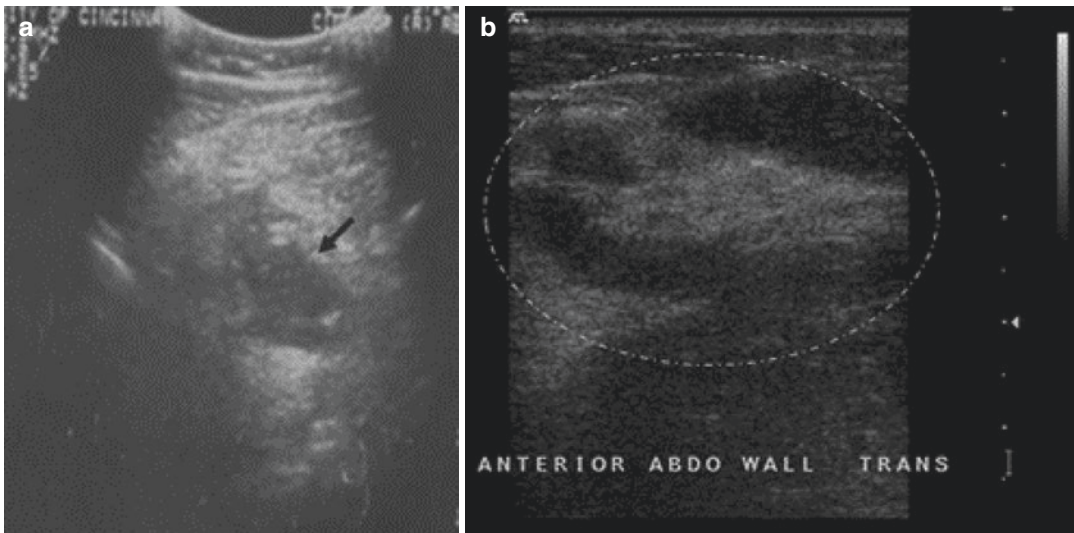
(a) Ultrasonographic study of a patient with abdominal pain and malaise. The study helped make the diagnosis of abdominal abscess (arrow) and provided
